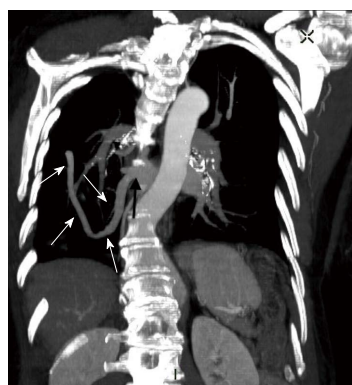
Contrast-enhanced maximum intensity projection multiplanar reformatted coronal image of the computed tomography chest demonstrating the path of the anomalous pulmonary vein (white arrows) and its connection to the left atrium (black arrow). R: Right.
